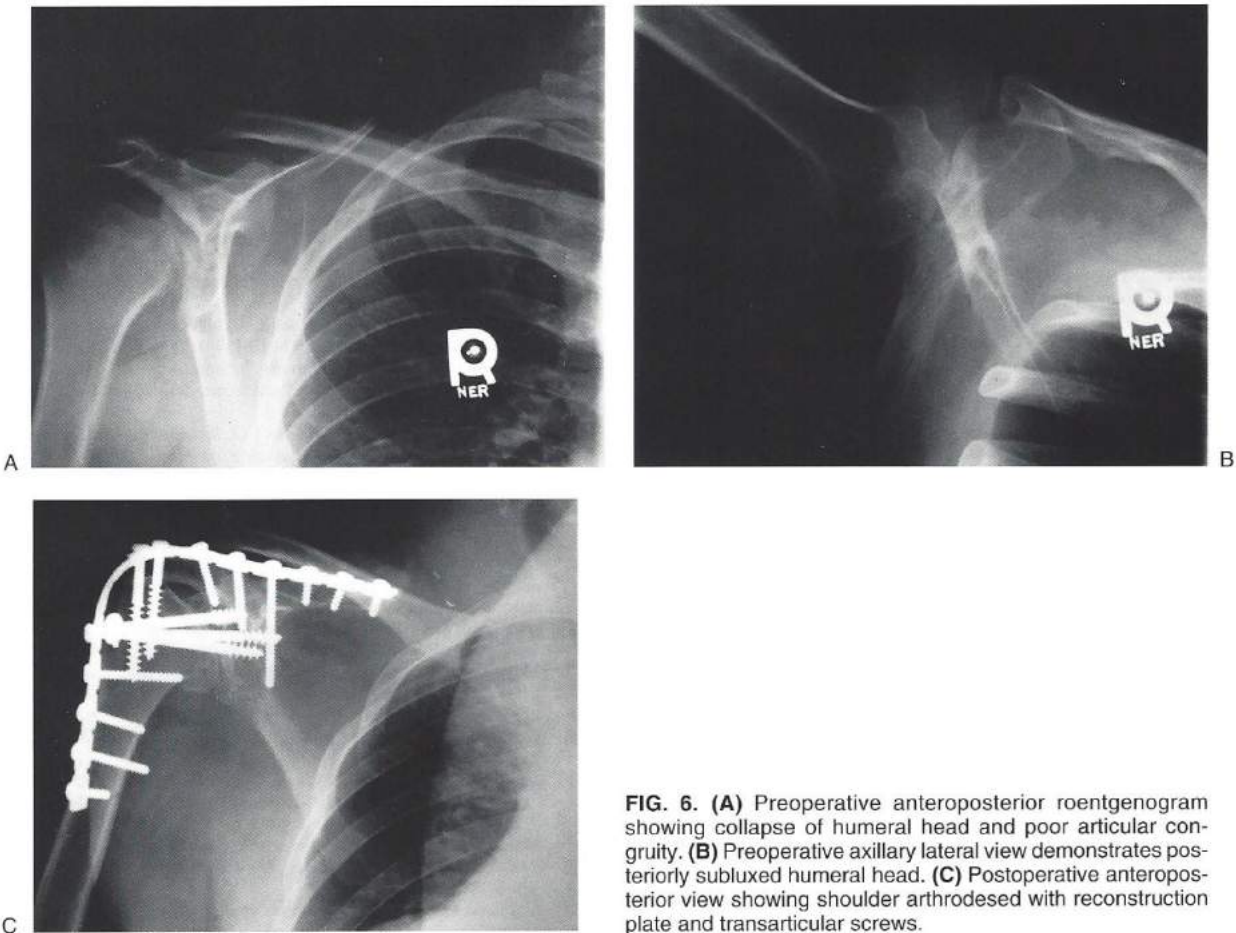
(A) Preoperative anteroposterior roentgenogram showing collapse of humeral head and poor articular congruity. (B) Preoperative axillary lateral view demonstrates posteriorly subluxed humeral head. (C) Postoperative anteroposterior view showing shoulder arthrodesed with reconstruction plate and transarticular screws.
